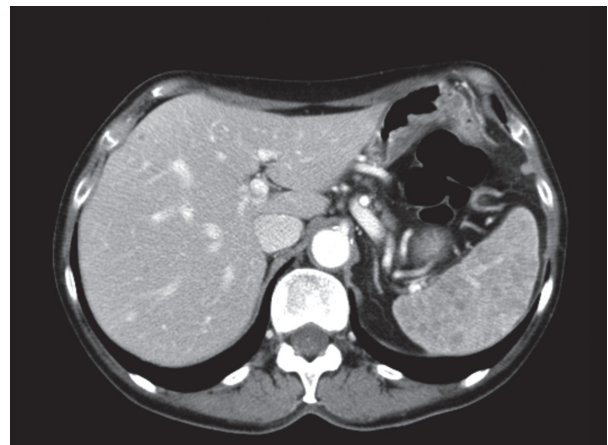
Third case: PET/CT showing multiple nodular lesions in the spleen
